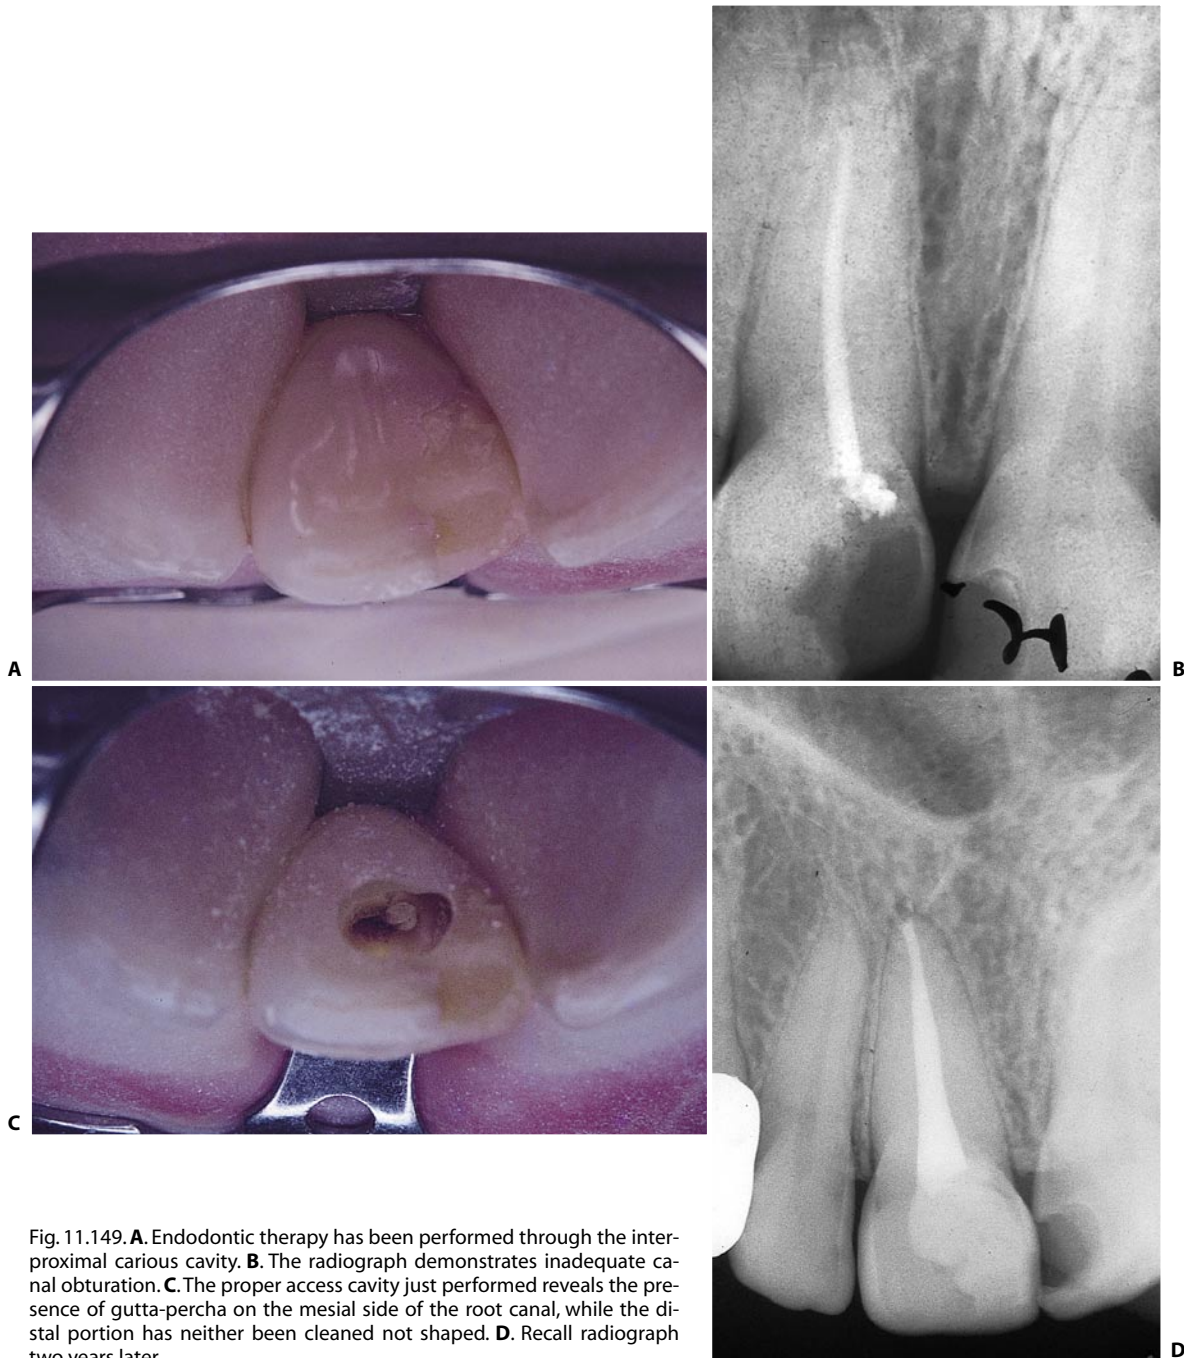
A. Endodontic therapy has been performed through the interproximal carious cavity. B. The radiograph demonstrates inadequate canal obturation. C. The proper access cavity just performed reveals the presence of gutta-percha on the mesial side of the root canal, while the distal portion has neither been cleaned nor shaped. D. Recall radiograph two years later.
